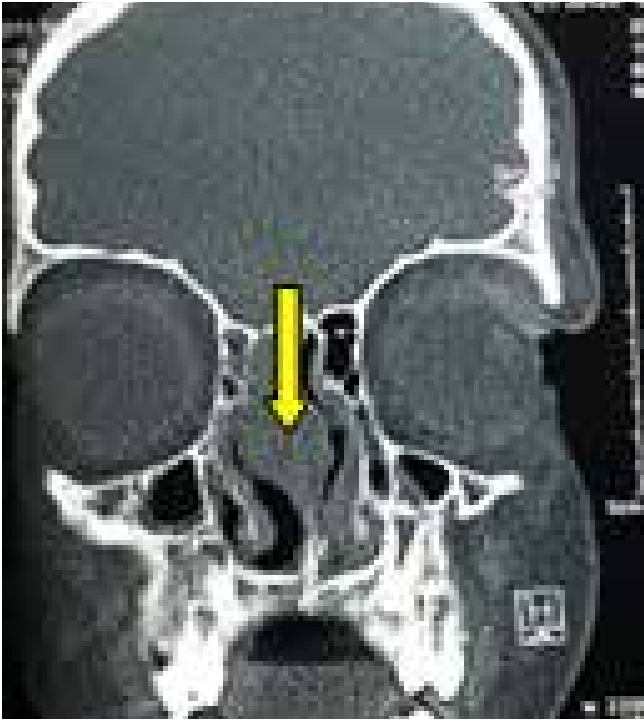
CT Nose and PNS showing defect in cribriform plate with soft tissue density in nasal cavity.
